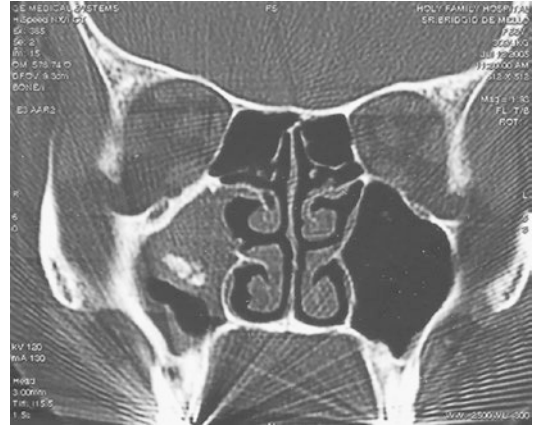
Coronal view of a CT scan showing the typical appearance of a fungal ball in the right maxillary sinus as a hyperintense mass
